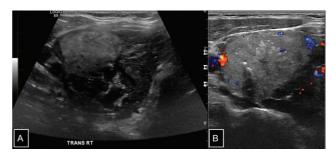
(A, B) Grayscale image on the left demonstrates the right lobe of the thyroid replaced by a large heterogeneous solid mass with stippled micro-and macro calcifications. Color doppler images on the right show increased peripheral vascularity.
